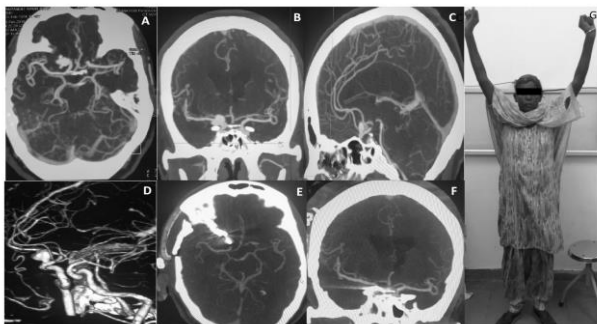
Computed tomography angiography of right ophthalmic aneurysm, axial view (A) showing multilobulated large aneurysm. Coronal view (B) showing the superiorly projecting aneurysm. Sagittal view (C) aneurysm with narrow neck. Three dimensional CT (D) showing large superiorly projecting ophthalmic aneurysms. Post op Computed tomography angiography (E and F) complete occlusion of aneurysm. (G) Patient is fine with no deficit.
